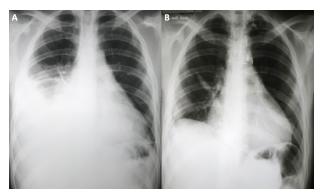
Chest radiography in posteroanterior view before and after percutaneous embolization of the thoracic duct. (A) Image shows moderate pleural leakage on the rightside view, after surgical procedure of correction of coarctation of the aorta correction and aneurysm of the ascending aorta and before percutaneous embolization of the thoracic duct. (B) Image one week after percutaneous embolization of the thoracic duct, with improvement in pleural leakage.
